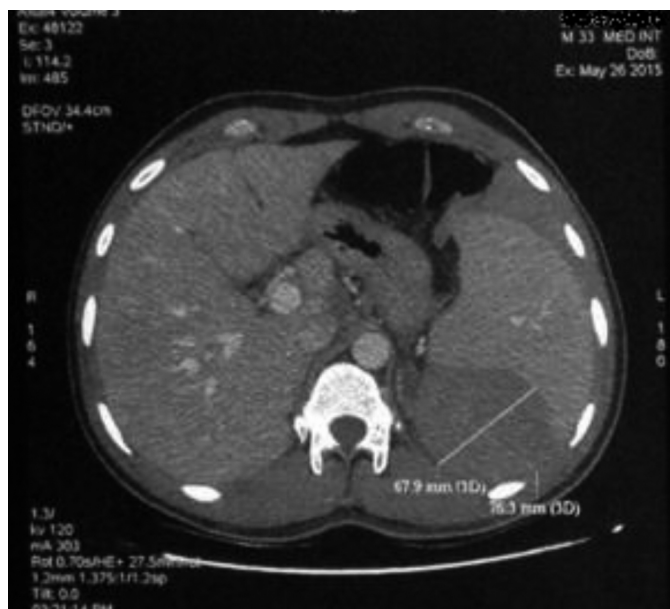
CT scan findings at the admission
